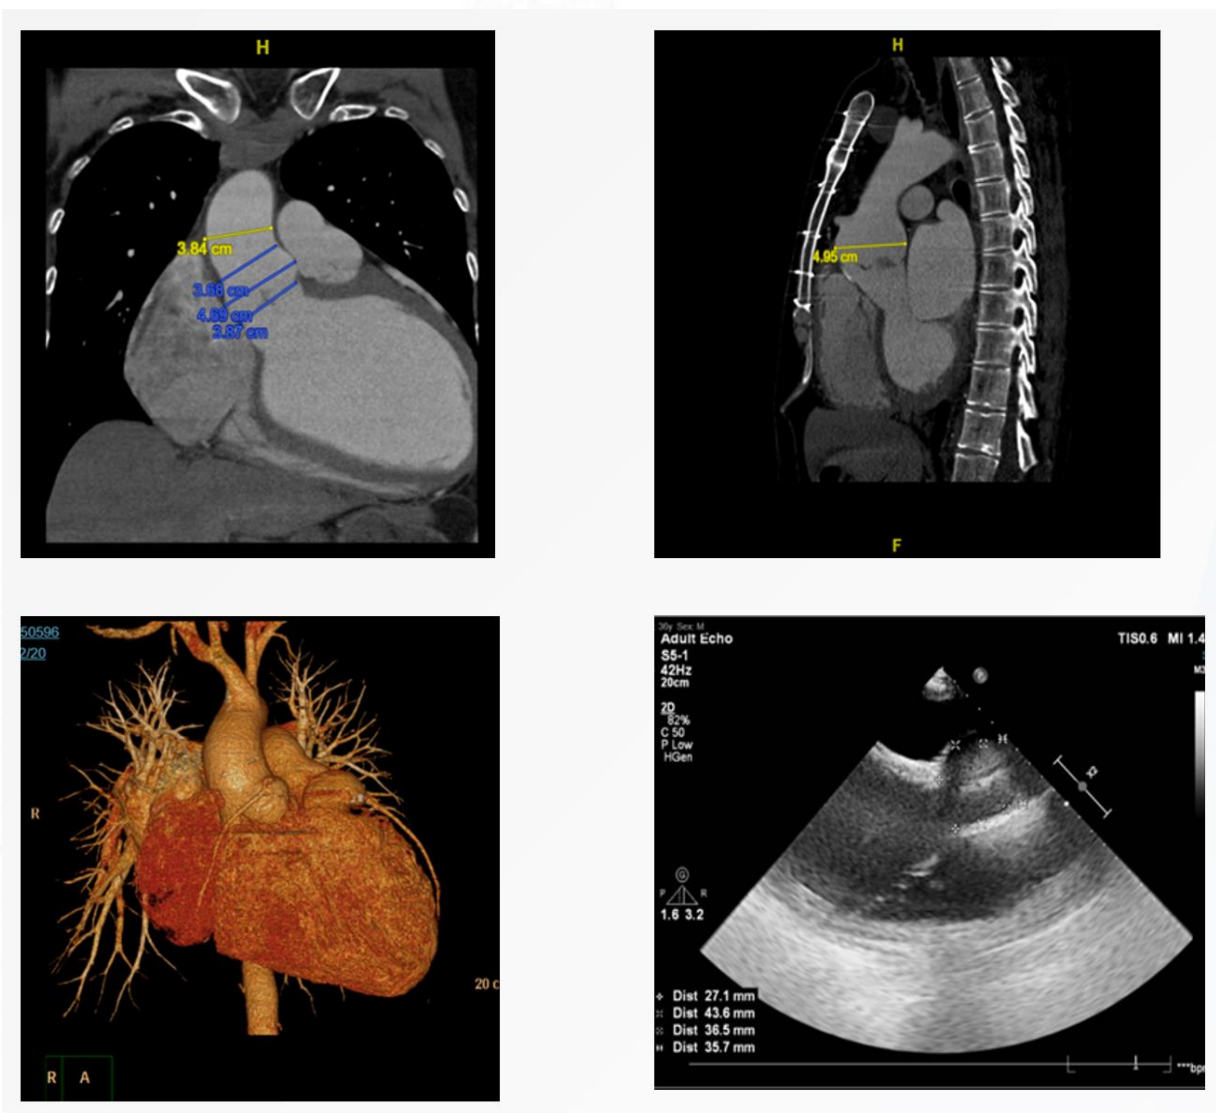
36 year male, underwent ICR for TOF 12 years back, now with dilated aortic root, severe AR & LV dysfunction with dilated LV (CT & Echo images)
